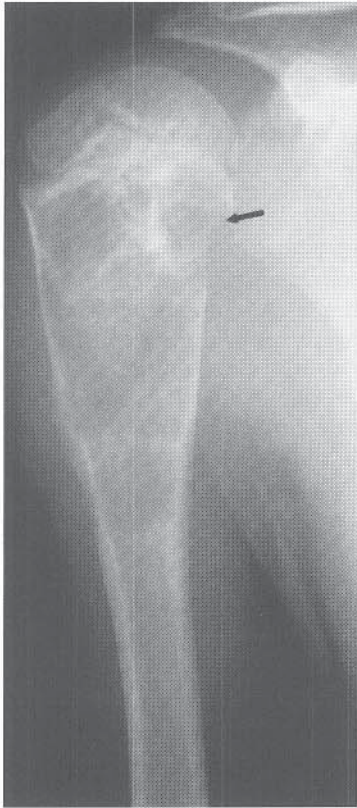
AP radiograph of the proximal humerus showing a fracture of the medial metaphysis (*arrow*) after minimal trauma. Note the large, expansile unicameral bone cyst.
